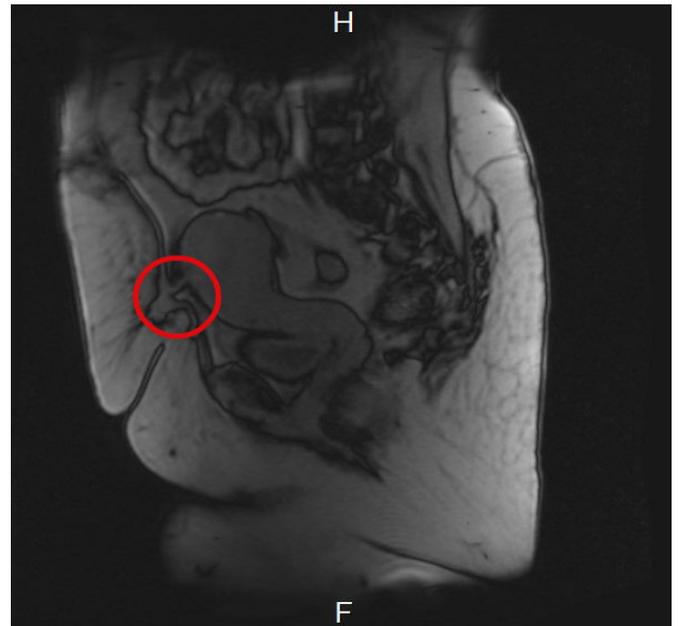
T2 MRI shows fistula extending from the uterus to the outside skin
